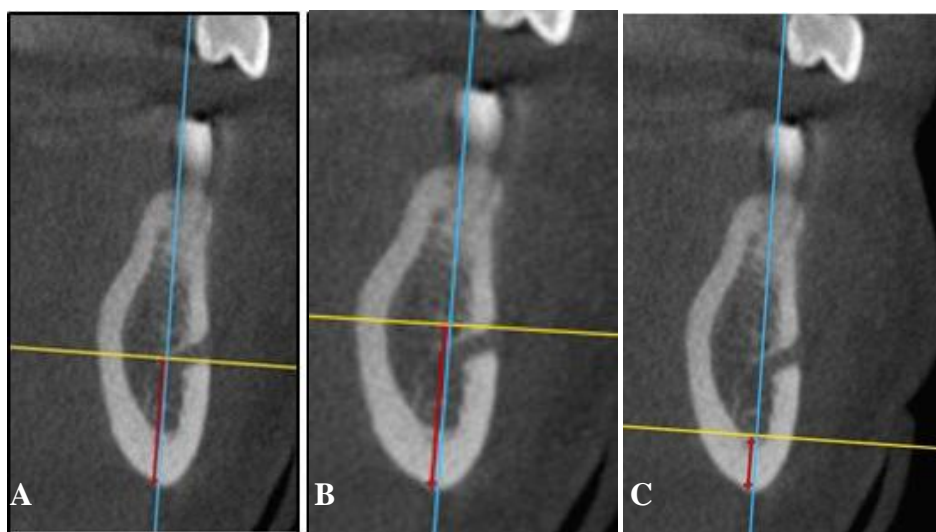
CBCT indices measurements.
